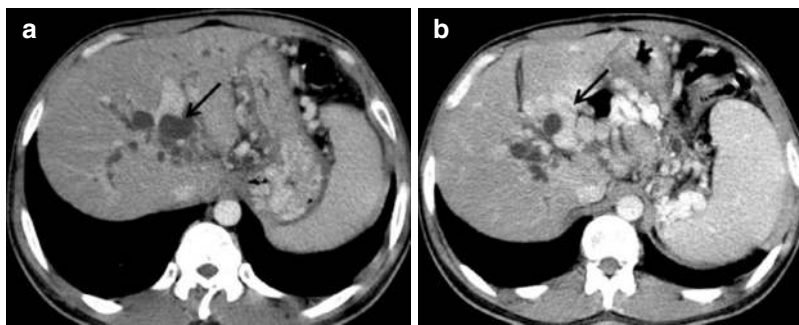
Portal cavernoma cholangiopathy. Contrast-enhanced CT (a, b) shows a cavernoma at the porta, replacing the main portal vein. Dilated intrahepatic biliary
